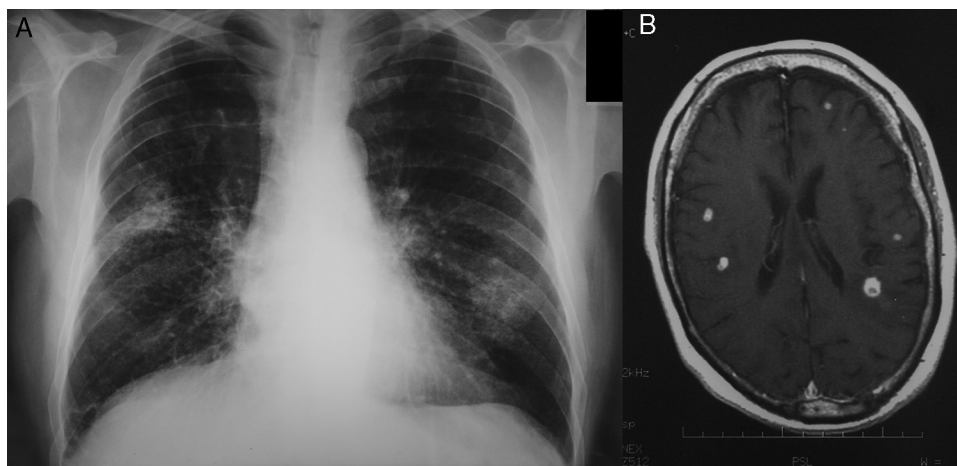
(A) Chest X-ray showing cavitated infiltrate in upper right lobe and infiltrate without cavitation in lower left lobe. (B) Head MRI showing multiple nodular lesions, less than 1 cm in size, in the cortical-subcortical region, and vasogenic edema.
